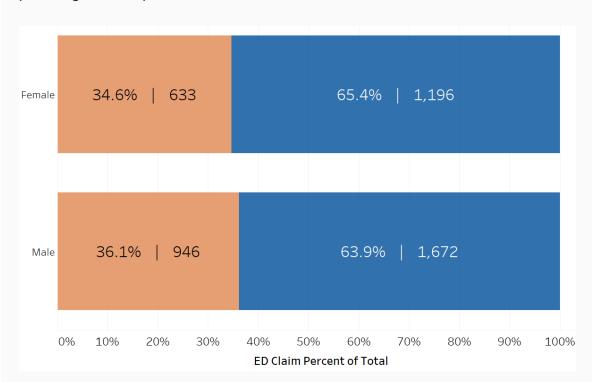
Breakdown by receipt of MRI during ED visit
